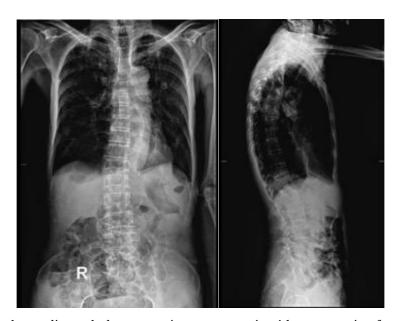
Vertebrothoracolumbar radiograph demonstrating osteoporosis with compression fractures of the 5th and 12th thoracic vertebrae.
